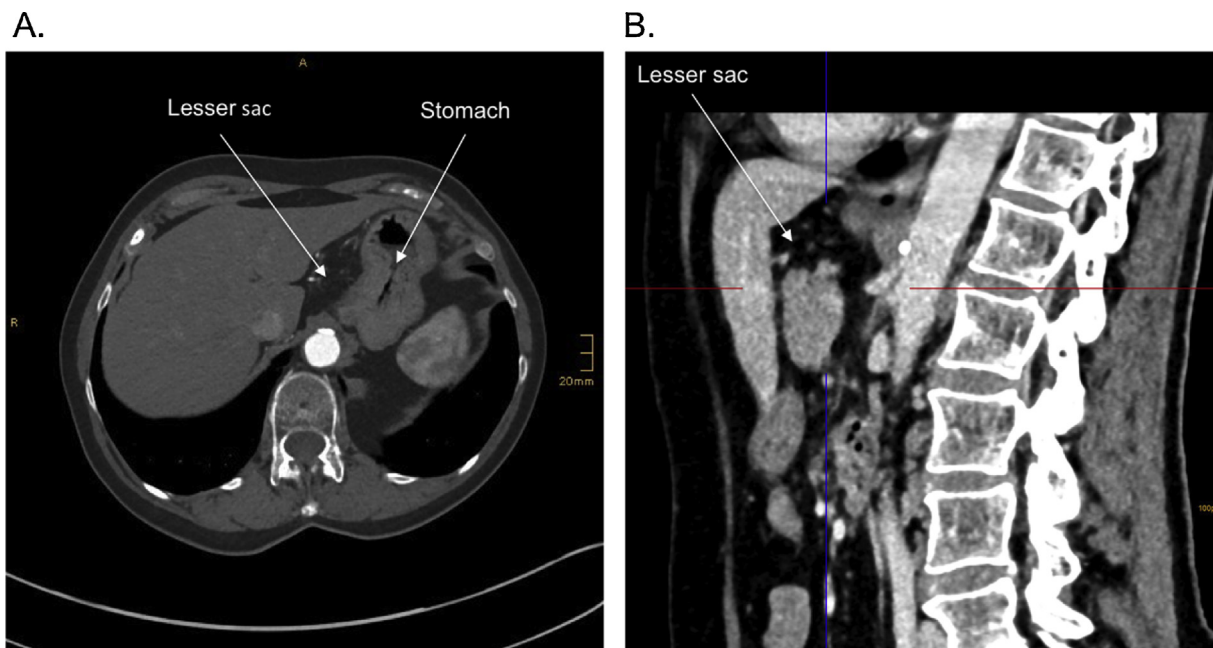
Abdominal computed tomography, one year after surgery.
